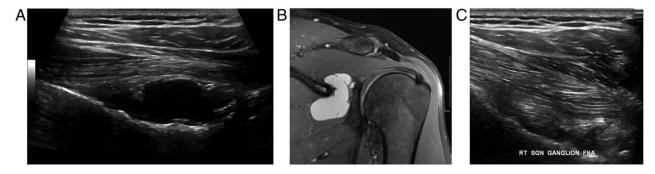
(A) Large septated ganglion cyst in the spinoglenoid notch. (B) Magnetic resonance image of a complex ganglion with a partial tear of the posterior labrum. (C) Ultrasound of the region after aspiration of the ganglion.
